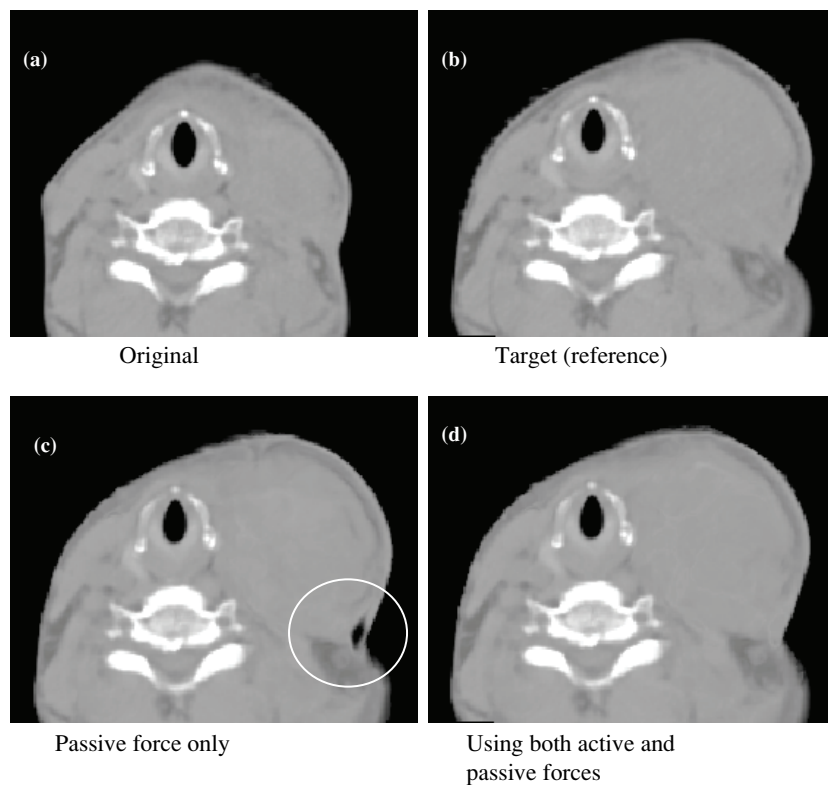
An example demonstrating that with the addition of ‘active force’ in the demons algorithm, better convergence can be achieved when relatively large deformations exist between a pair of images. (a) The original CT slice; (b) the target (reference) CT; (c) resultant CT image deformed from (a) to match with (b) using the passive-force only demons algorithm. Notice the circled area, in which the algorithm did not converge and left a hole in the area; (d) resultant CT image obtained by using both passive and active forces demons algorithm. The image in (d) matched well with the reference image in (b), demonstrating a superior performance by the implemented demons algorithm.
